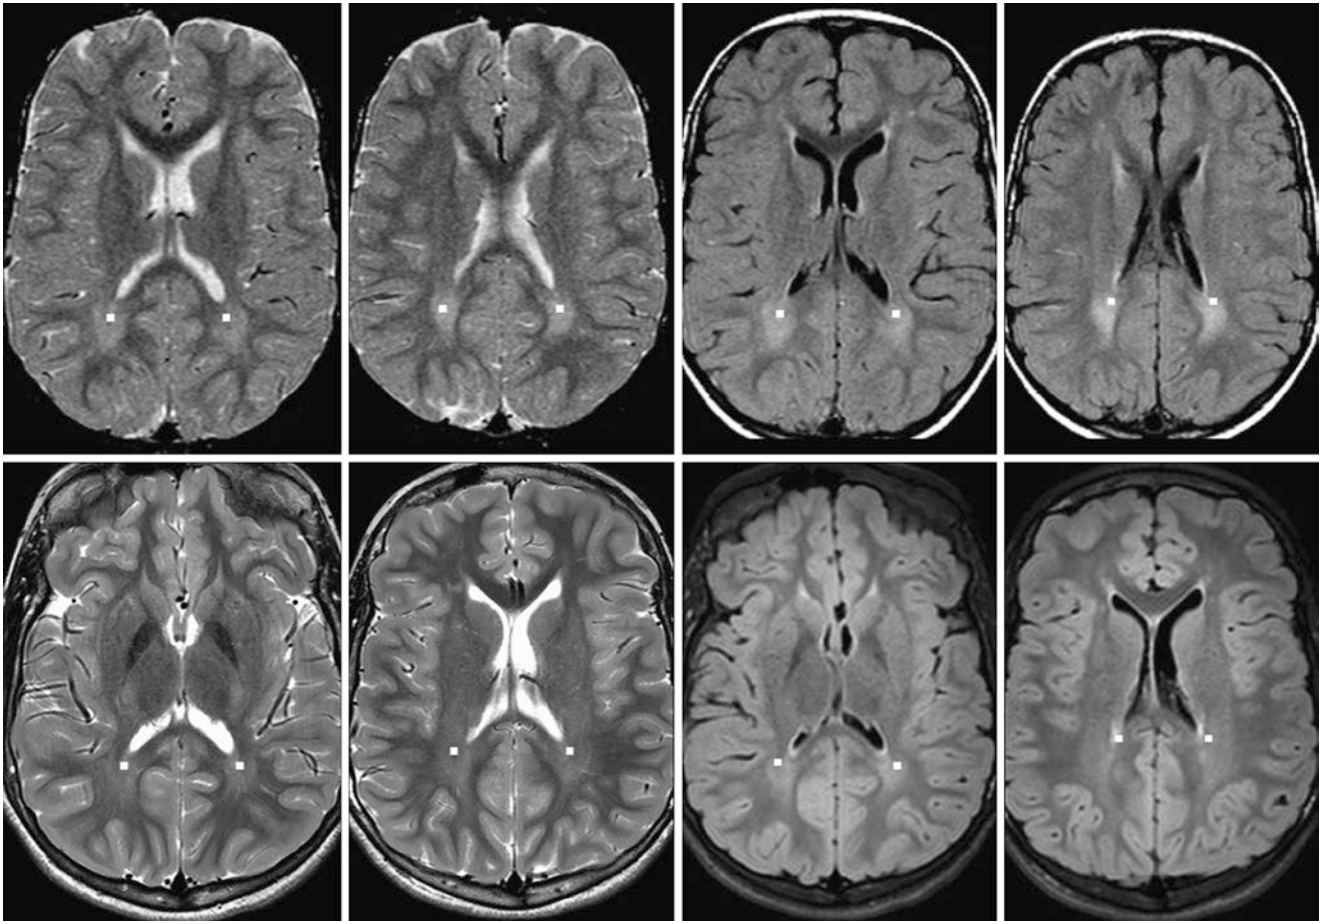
A 4.0-year-old with autism. *Top row:* 1.5T SE T2WI (*left images*) and FLAIR (*right images*) showed patchy terminal zone regions of incomplete PTWM maturation (*squares*). *Bottom row:* A 3T
